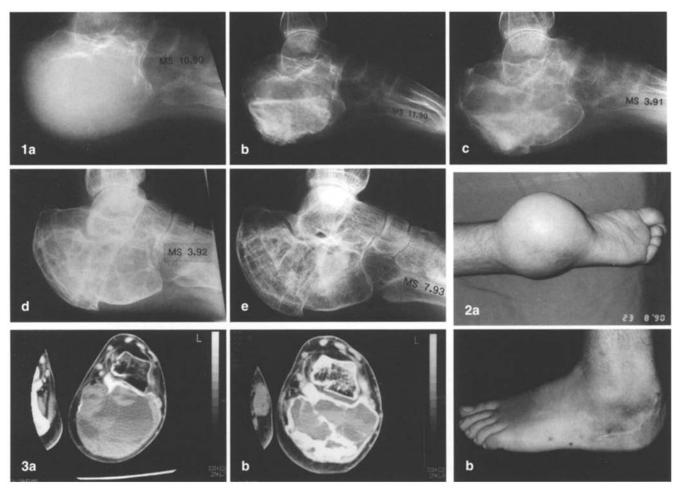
Case 1. Lateral radiographs of the "blow out" calcaneum and the aneurysmal bone cyst (ABC) and its progressive healing after bone paste implantation. a Preoperative lateral radiograph of the calcaneum. b Immediate postoperative lateral radiograph showing the incomplete packing of the cyst by the partially demineralized bone particles. c Four-month aspect of the calcaneum on the lateral radiograph showing a well delineated peripheral shell of new bone. d Progressive development of an irregular ossification throughout the cavity at 16 months after surgery. e Lateral radiograph at 32 months after surgery showing the enlarged but fully ossified calcaneum which required surgical reduction twice to allow her to wear shoes
